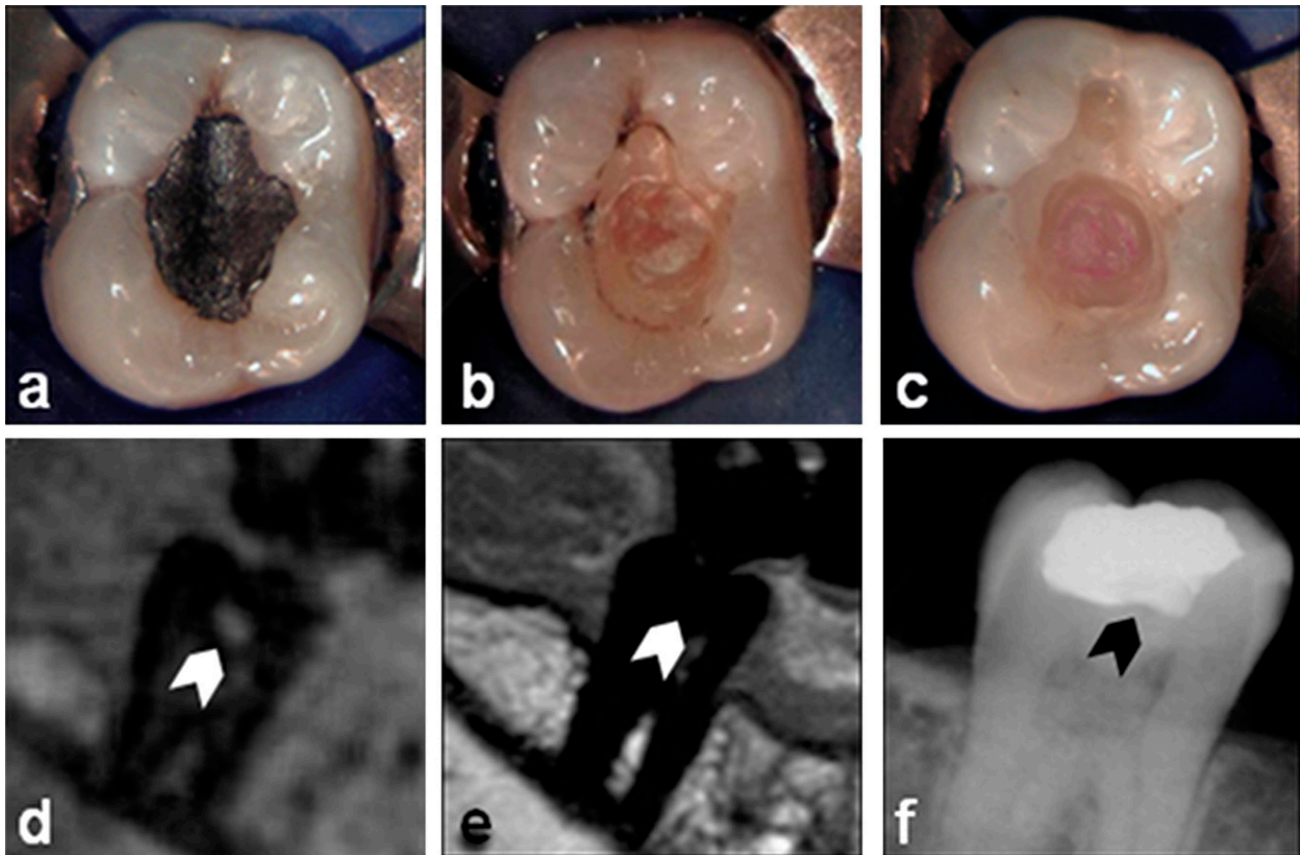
Secondary caries (CIII): intraoral pictures of dental treatment (a) prior to the treatment, (b) after filling removal and (c) after excavation, and the respective three-dimensional ultrashort echo time (d) multislice turbo spin-echo (e) and X-ray (f) images. Lesion position is marked by an arrow
